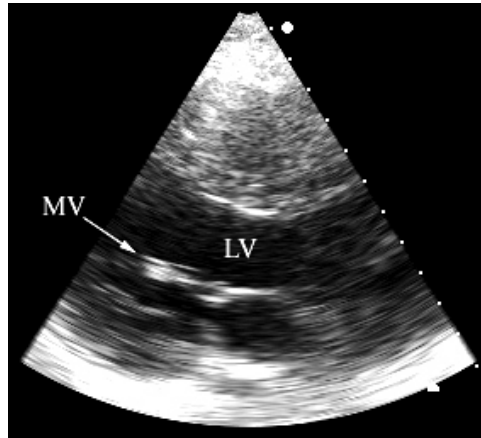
B-scan ultrasound image The image shows an oblique long axis view of the heart with the left ventricle (LV) and mitral valve (MV).
